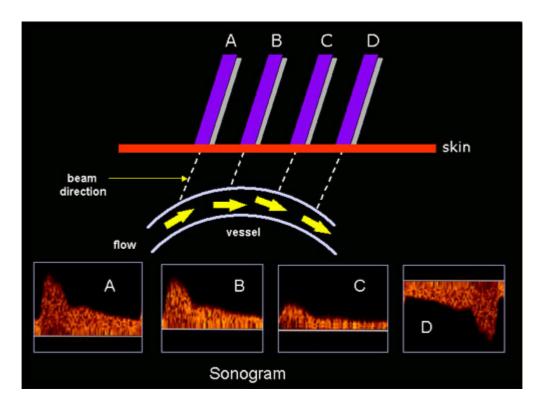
The effect of the Doppler angle in the sonogram. A higher signal is obtained if the beam is aligned more to the direction of the flow, as is shown in figures A) to C), where the beam is perpendicular to the flow and the signal very poor. In D) the flow is away from the beam resulting in a negative signal. Obtained from [139], figure 3.
